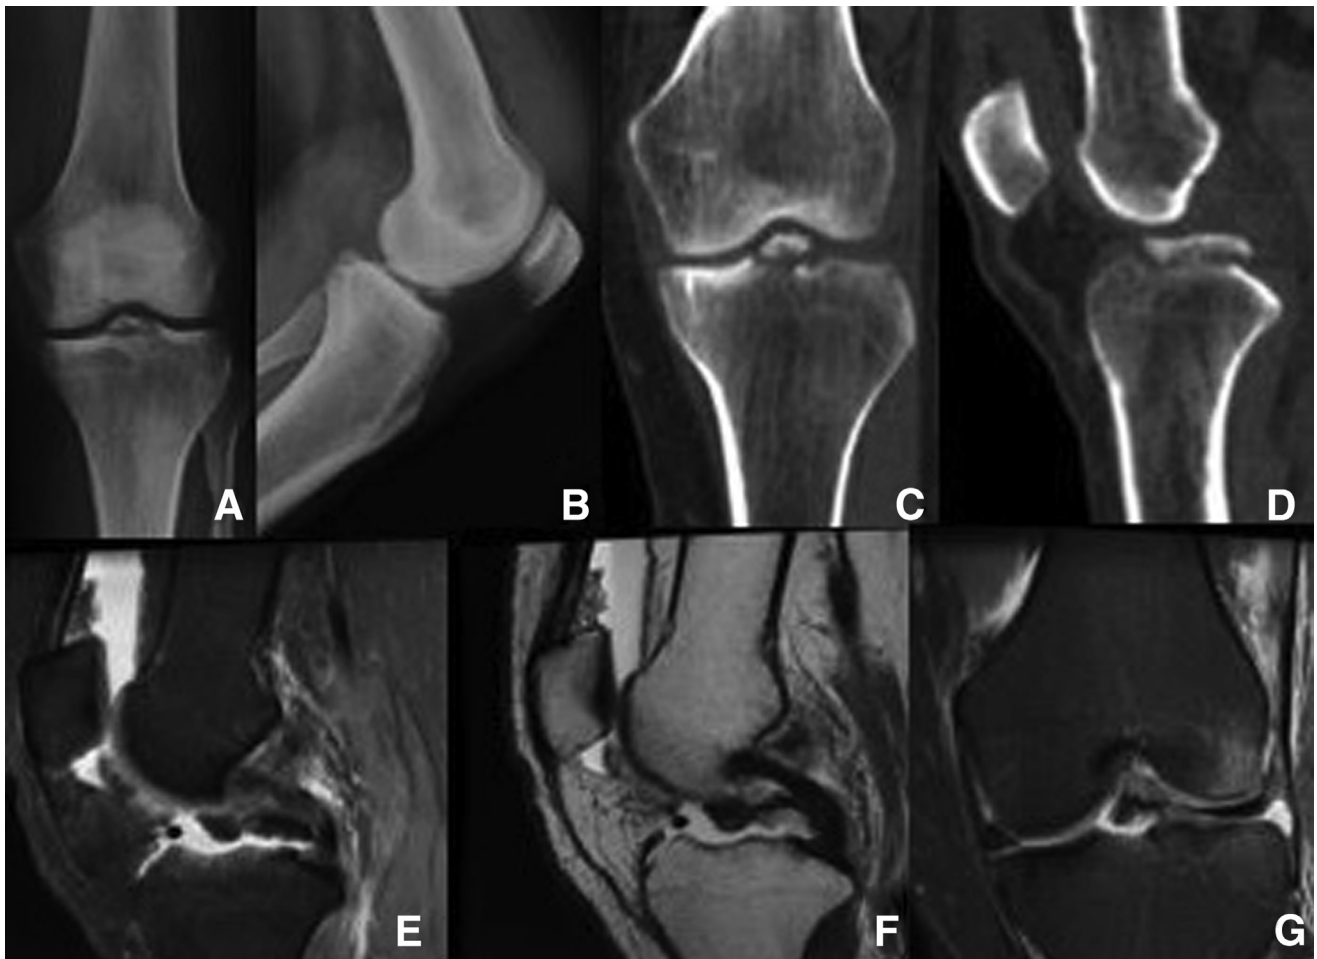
The plain knee radiographs (A, B) and computed tomography scan (C, D) of a patient with ACL avulsion fracture type 3 according to Meyers and Mckeever.⁵ On magnetic resonance imaging, the patient had no evidence of ligamentous or meniscus injury (E-G). (ACL, anterior cruciate ligament.)
